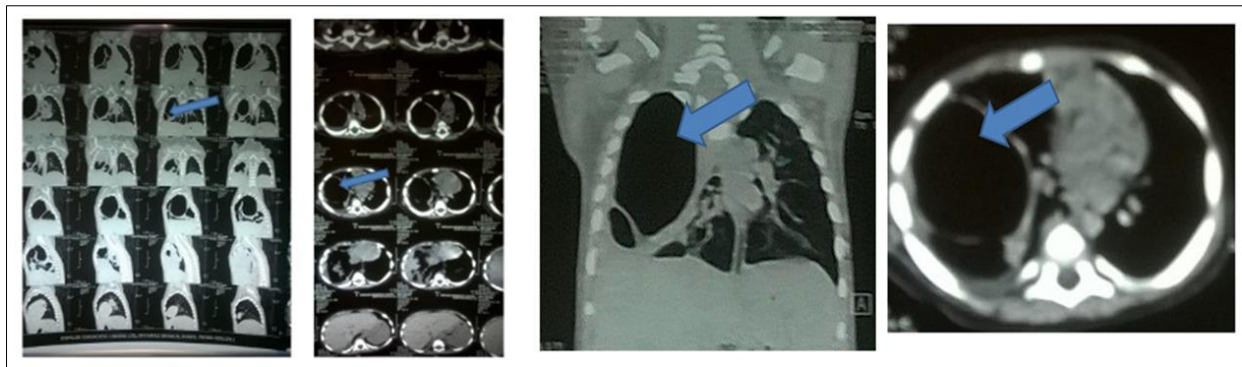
HRCT chest shows emphysematous changes with multiloculated area in right hemithorax with dense opacified base of lung
